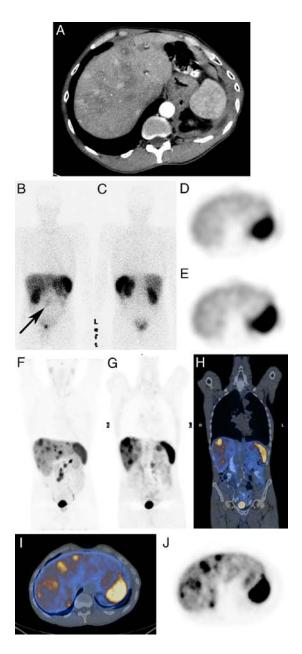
1. Combined images demonstrating lesions using CT/ PET and 111In-DTPA-Octreotide scintigraphy. A 69 year old male patient with a low grade metastatic midgut NET, A) Arterial phase CT scan identifying multiple arterial enhancing and low attenuation liver metastases. B & C) Anterior and posterior whole body ¹¹¹In-DTPA-Octreotide scintigraphy showing low grade (Krenning score =1) mesenteric metastases (see arrow) but no liver metastases. D & E) SPECT axial images at level of spleen with heterogenous liver uptake and no discernable liver deposits. F) Maximum intensity projection (MIPS) image with ⁶⁸Ga-DOTATATE PET showing multiple deposits in the liver and mesentery. G) ⁶⁸Ga-DOTATATE PET coronal section anterior to the kidney shows multiple liver metastases. H) Fused ⁶⁸Ga-DOTATATE PET/CT image of figure 1G. I) Fused axial ⁶⁸Ga-DOTATATE PET/CT image at level of spleen showing multiple liver metastases. J) ⁶⁸Ga-DOTATATE PET axial image at level of spleen showing multiple liver metastases.
